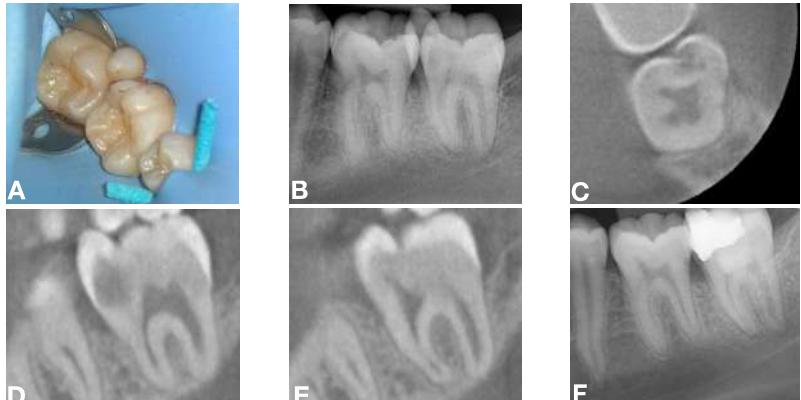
Preoperative intraoral photograph of the lower left second molar (#37) (A), preoperative radiograph (B), preoperative CBCT (C-E) and postoperative radiograph (F).
